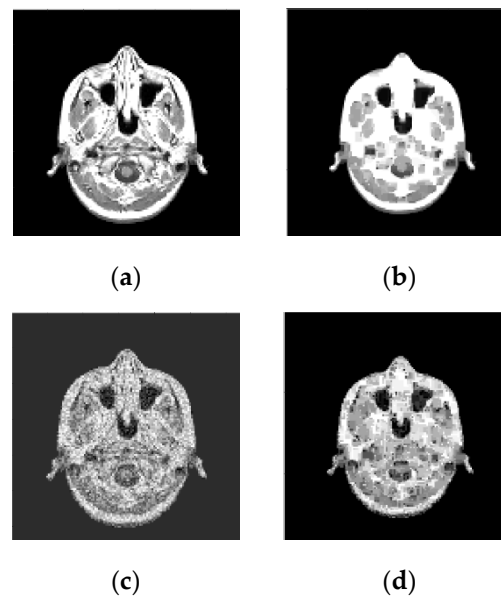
Results of reconstruction of MRI image based on qualitative data. (a) Original image; (b) Reconstructed image; (c) Original noisy image; (d) Reconstructed noisy image .
